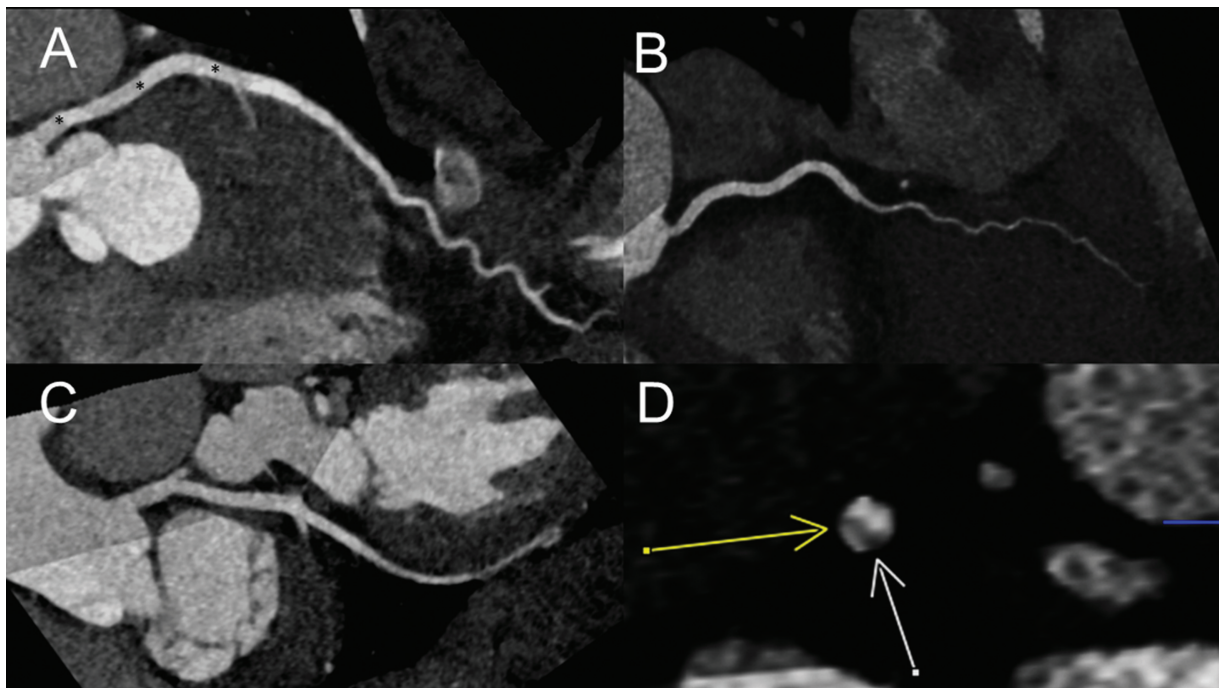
Coronary CTA: Multiplanar reformatted images of the LAD (A), LCx (B), and RCA (C) demonstrate absence of atherosclerotic plaque and obstruction. A subtle nonobstructive flap was evident in the left proximal to mid-LAD (asterisks in A). The intimal flap is confirmed to be nonobstructive in a double-oblique short axis reformat (arrows, D) of the LAD, with contrast opacifying both the true and false lumens albeit at different intensities. No intramural hematoma was identified throughout the visualized course of the coronary arteries. The distal LAD and LCx are notably somewhat tortuous. CTA, computed tomography angiography; LAD, left anterior descending artery; LCx, left circumflex artery; RCA, right coronary artery.
